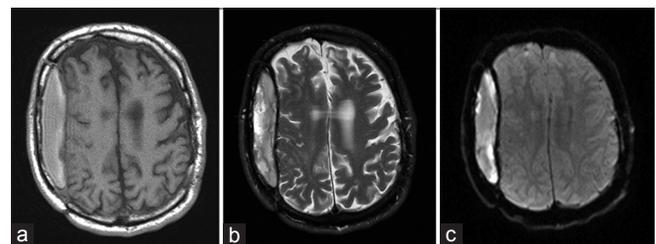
MRI of the brain without contrast on the day of admission. (a) T1WI showing hyperintense extraaxial fluid collection within the bounds of previous craniotomy on the right side. (b) T2WI showing hyperintense extraaxial fluid collection within the bounds of previous craniotomy on the right side. Both of these findings were consistent with late subacute SDH. (c) DWI shows some diffusion restriction within the extraaxial fluid collection on the right side. This was felt to be nonspecific secondary to history of previous extraaxial blood
